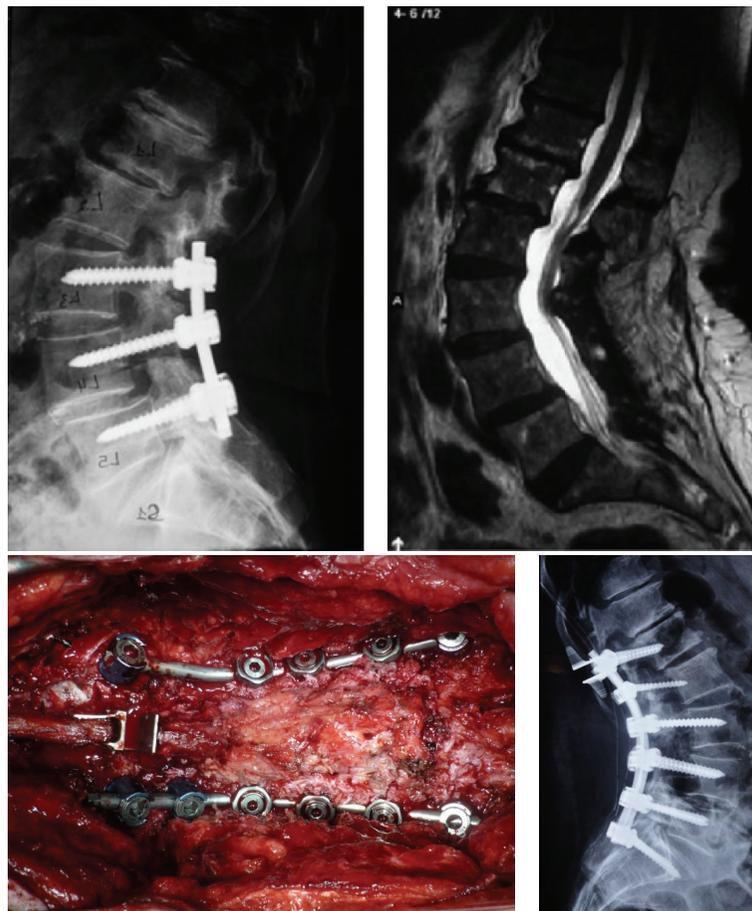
Above preoperative spine X-ray with previous instrumented level on the right. On the left, degenerated segments at L1-L2 and L2-L3 levels. Below preoperative view showing the extended fusion from L1 to S1 with Th12-L1 interspinous spacer.
